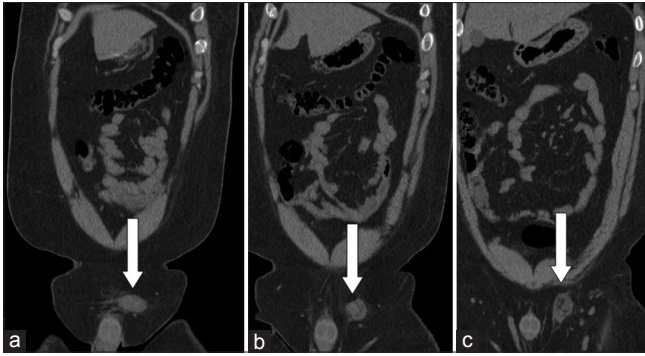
(a) Coronal reformat of non contrast computed tomography shows cryptorchid left testis in the left inguinal canal (white arrow). (b and c) Serpentine twisting soft tissue density structures proximal to it representing twisted spermatic cord (white arrows)
